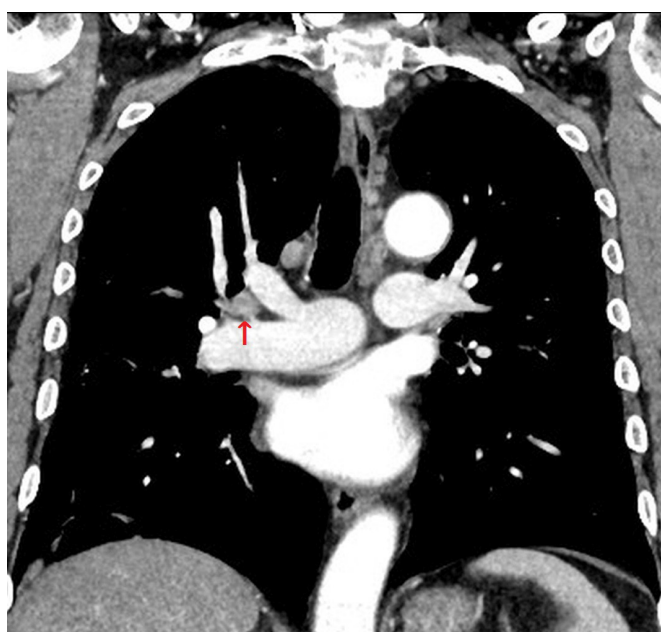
CT scan in coronal plane showing mediastinal lymph node enlargement (arrow).
